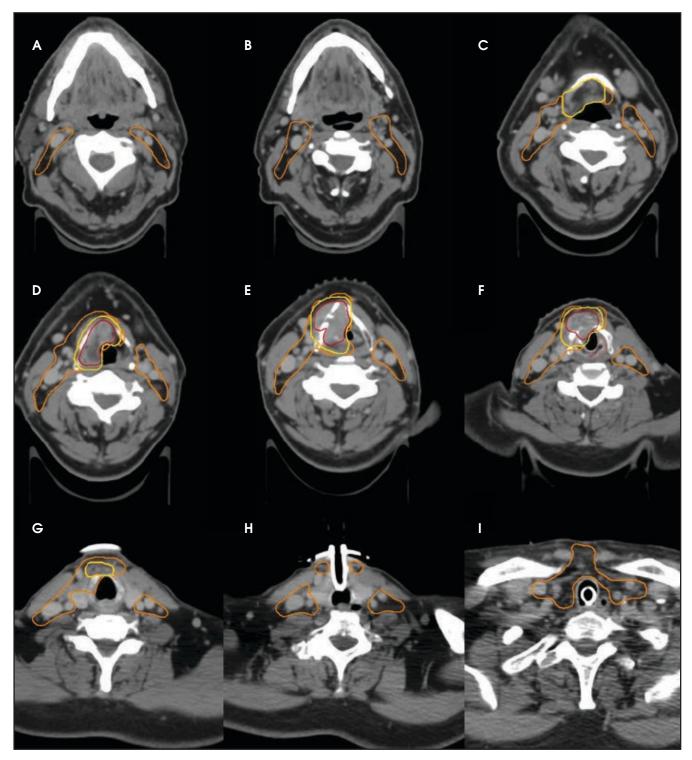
Axial CT treatment planning images of the GTV70 (red), CTV70 (yellow), and CTV56 (orange) are shown for a patient with locally advanced larynx cancer. Outlined in pink is a larynx avoidance structure used for IMRT planning to reduce the dose to the contralateral side (F). In addition to levels II-IV bilaterally, level VI was also included in the CTV56 volume (I), given the anterior disease extent. The GTV70 to CTV70 expansion was 3 mm, and the PTV expansion was 2.5 mm. The patient was treated with daily cone-beam computed tomography (CBCT) IGRT. Please note these are representative slices and not all slices are included.
